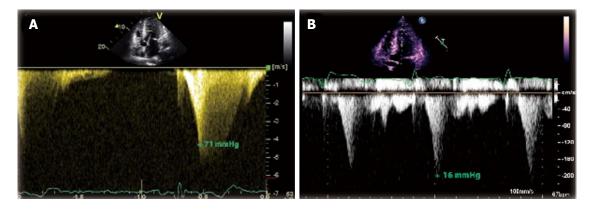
Transthoracic echocardiogram continuous Doppler. A: Transthoracic echocardiogram continuous Doppler flow across the left ventricle. The mid-cavitary gradient at rest from two years prior to the left-ventricular apical aneurysm (LVAA) formation (71 mmHg) is shown; B: Over time, flow across the mid-cavitary obliteration decreased and the peak pressure declined after the formation of the LVAA (16 mmHg).
